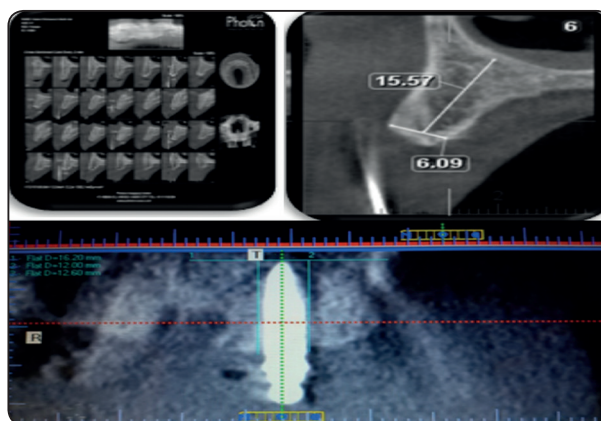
Radiographic diagnosis and follow up measurement
